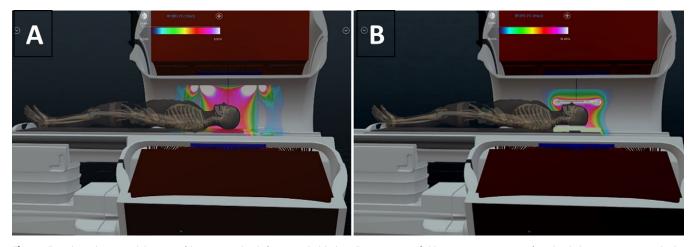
Three-dimensional depiction of the transmitted radiofrequency (RF) (B₁) oscillating magnetic fields in a 1.5-T MRI scanner for unloaded MRI scanners or coils. The near side of the scanner has been rendered transparent so that the energies/fields can be depicted three-dimensionally throughout the MRI scanner bore. (A) The spatial distribution of the transmitted RF (B₁) oscillating magnetic fields with the body RF coil of the scanner being used as the RF transmitter hardware is depicted. (B) The spatial distribution of the transmitted RF (B₁) oscillating magnetic fields with a transmit-receive head RF coil being used as the RF transmitter hardware is depicted. Note how the transmitted RF fields cover a smaller volume when a transmit-receive head RF coil is used for RF transmission in the same scanner. Images courtesy of Emanuel Kanal, MD, Presbyterian University Hospital, University of Pittsburgh Medical Center, created using Magnet/Sion (Advanced Magnetic Analytics).
